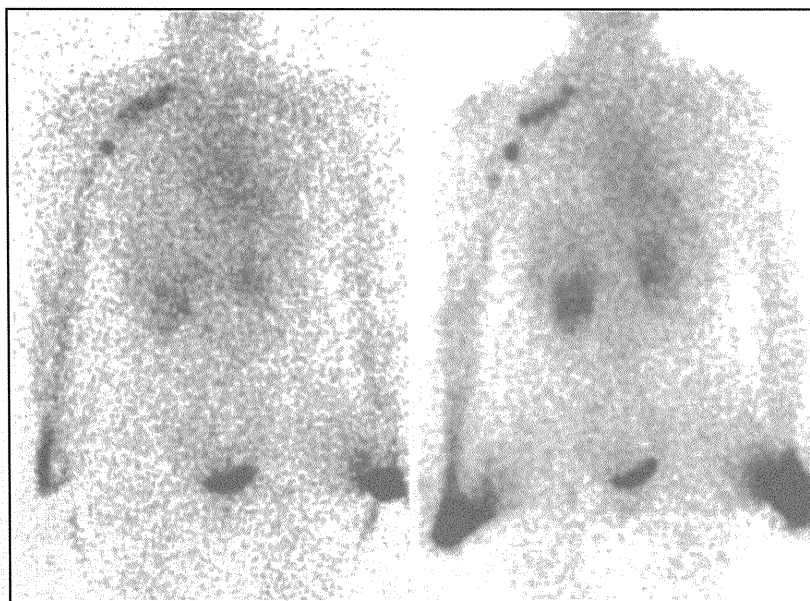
Lymphoscintigraphy images of a case of Type V-Subtype 0 lymphedema in the left arm. The left and right panels show images taken 30 and 120 min, respectively, after injection of a contrast medium. Lymph nodes around the clavicle were not observed even on the image taken at the later time point. DBF was found only in the hand.
